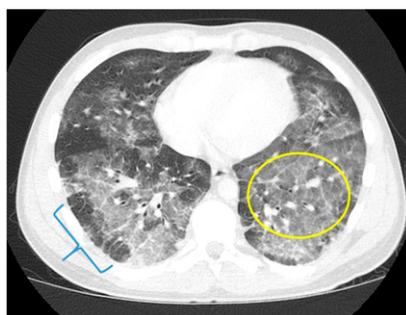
Axial CT image of the chest in a lung window reveals extensive GGOs with superimposed septal thickening creating a crazy paving pattern (circle) and with an area of subpleural sparing in the right lower lobe (bracket).
